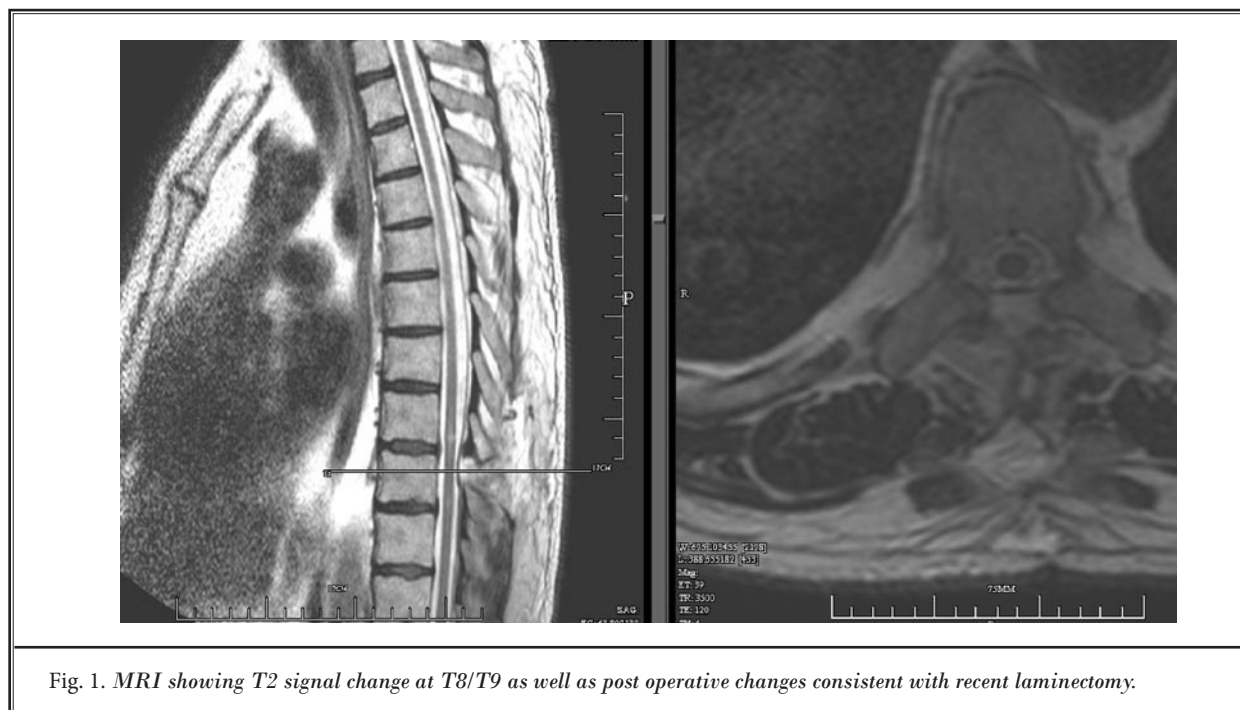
MRI showing T2 signal change at T8/T9 as well as post operative changes consistent with recent laminectomy.
